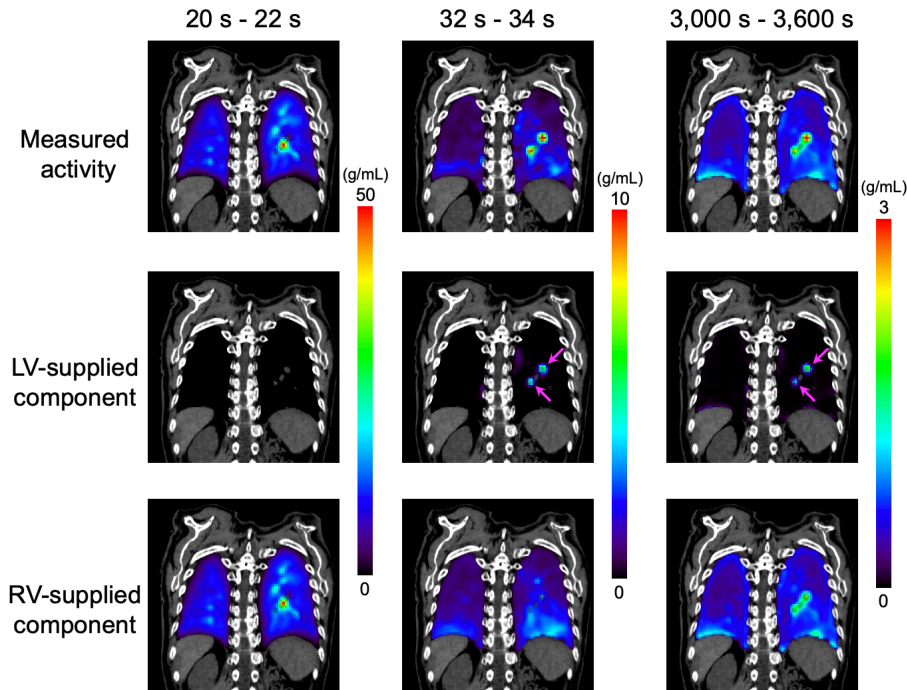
Dynamic ^{18}F -FDG images of a cancer subject with lung metastases (top) were decomposed into the LV-supplied component (middle) and the RV-supplied component (bottom) using the DBIF model. The ^{18}F -FDG PET images are overlaid on the corresponding CT slice, and the arrows point at metastases.
